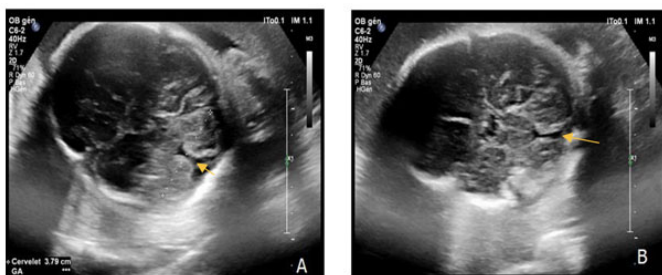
Neurosonography showing cerebellum and complete agenesia of cerebellar vermis (A, B), measurement of cerebellum (A). The yellow arrow shows the cerebellar vermis agenesia with a communication between the 4th ventricle and the cisterna magna.
